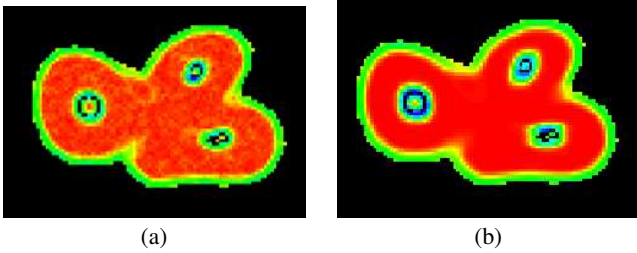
Slice from the *tooth* dataset, an industrial CT scan of a human tooth, which was part of the transfer-function bake-off. (a) shows slice with colormap of gradient signature, while (b) shows slice with colormap of 2nd order moment signature.
